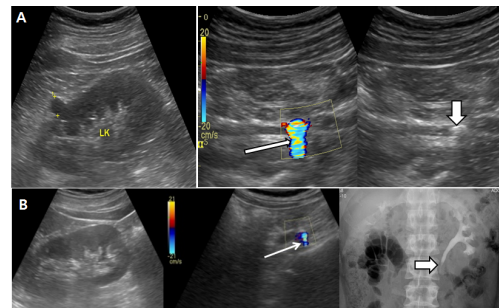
Ureteral stone with twinkling artifact. A. Color Doppler application of the kidney without the presence of hydronephrosis: a middle ureteral stone with twinkling artifact posterior (thin arrow) to the hyperchoic focus (fat arrow). B. Color Doppler of the kidney application without the presence of hydronephrosis: a suspicious upper ureteral stone with a posterior weak twinkling artifact (thin arrow) and an intravenous urography examination shows a sudden ureteral closure (fat arrow)
